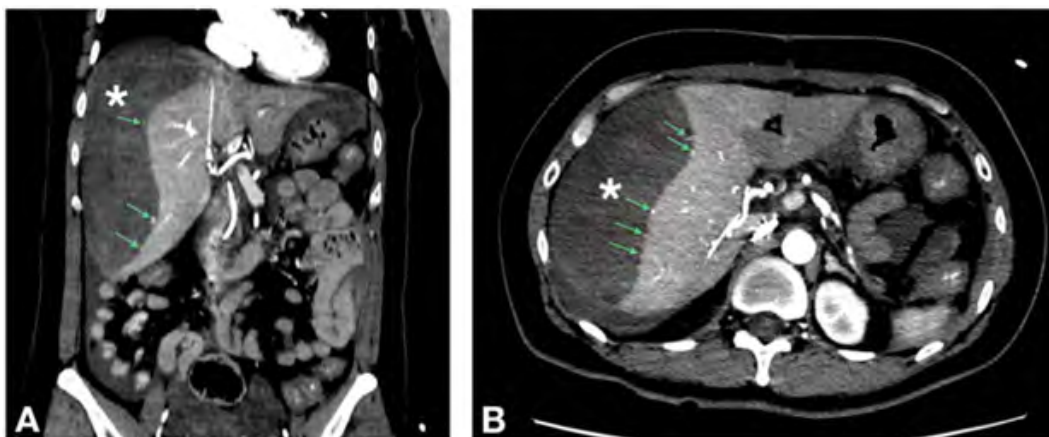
Coronal (A) and axial (B) reconstruction of abdominopelvic CT showing a huge subcapsular hepatic hematoma (white asterisks) with multiple blood leakage points (green arrow).
